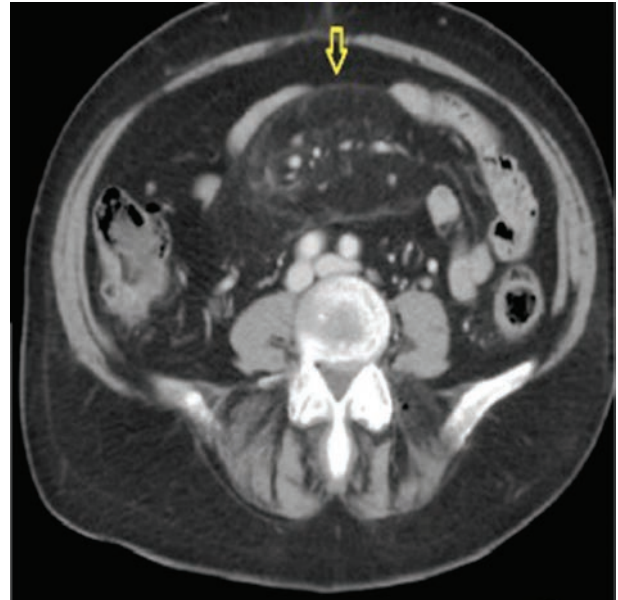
The axial contrast enhanced CT image shows a large mesenteric mass with a pseudocapsule (yellow arrow), lymph nodes and vessels inside the mass and displacement of the surrounding bowel
